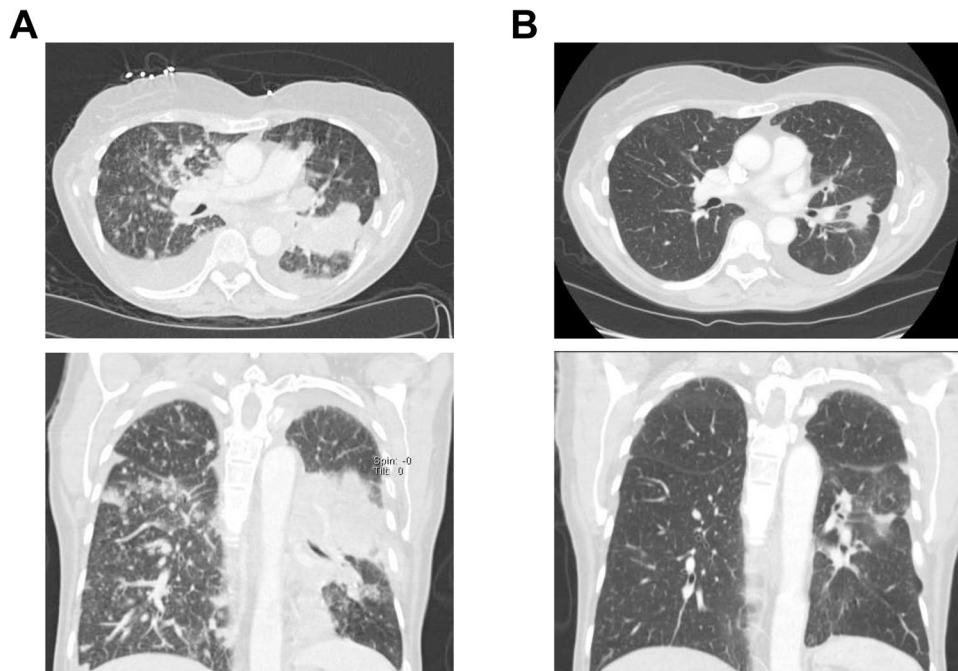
Clinical response of a *ROS1*-rearranged patient to crizotinib. (A) Axial (top) and coronal (bottom) computed tomography images of the chest before crizotinib. (B) Axial (top) and coronal (bottom) computed tomography images of the chest after 6 weeks of crizotinib, demonstrating a dramatic improvement in the left lung mass, bilateral pulmonary nodules and pleural effusions.
